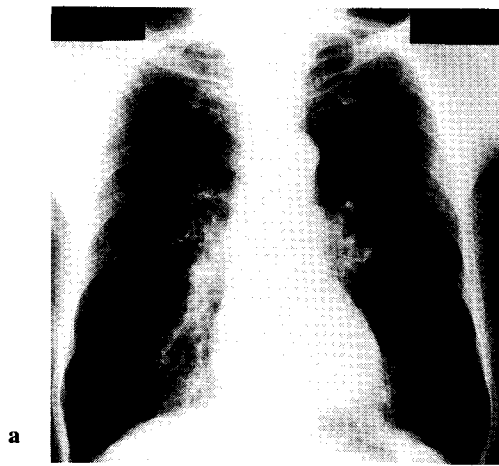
Case 20. A 69-year-old male. Cigarette index: 900. Chest X-ray film shows the narrowing of pulmonary vessels especially in the upper and lower lung field (a). Planar images of Technegas scintigraphy, Stage IV, shows heterogeneity of the peripheral lung field (b). SPECT, Stage IV, shows heterogeneity, hot spot formation and defects throughout the peripheral lung field: upper (c-i); middle (c-ii); and lower (c-iii) lung fields. In this case, planar and SPECT images are equivalent.
